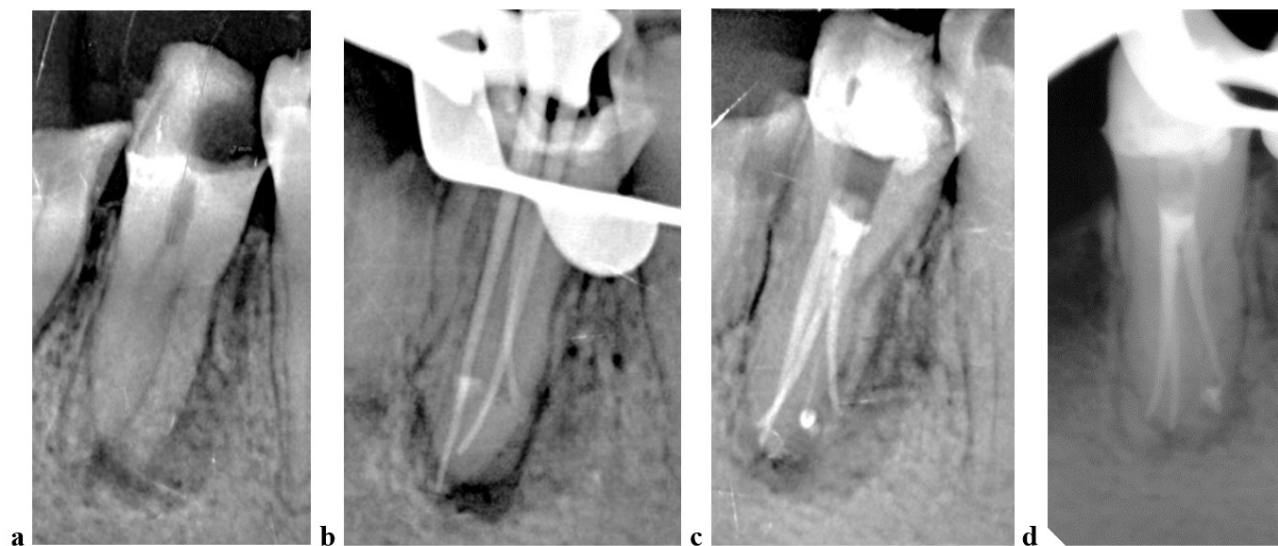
(a) pre-operative radiograph (b) mastercone radiograph (c) obturation completed (d) 2 months follow-up.
